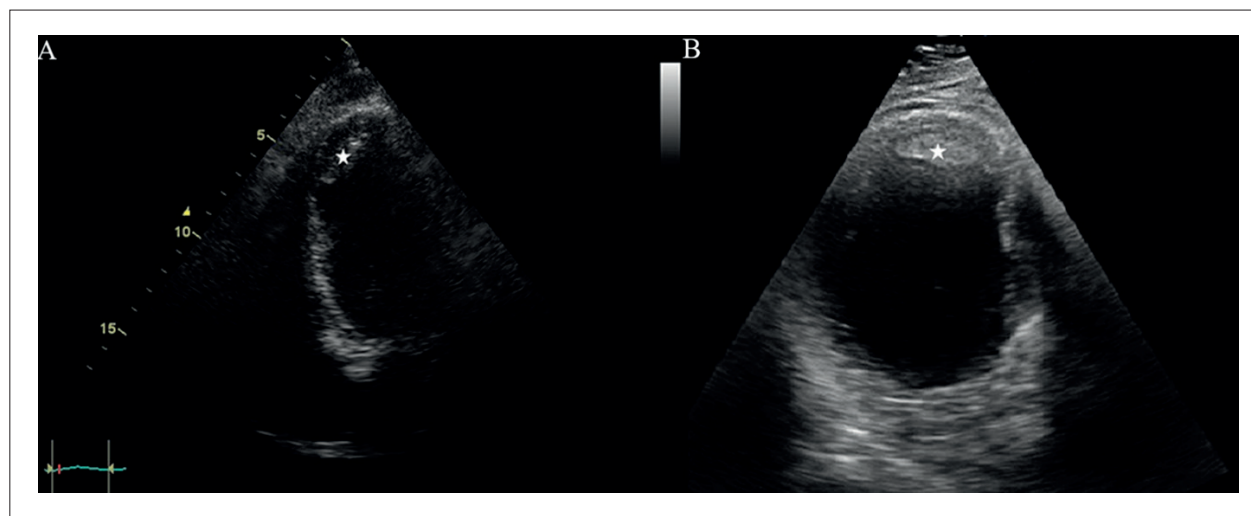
Transthoracic echocardiographic view of a thrombus (asterisk) in the apex of the left ventricle. A: 45-year-old male patient, B: 56-year-old female patient.
